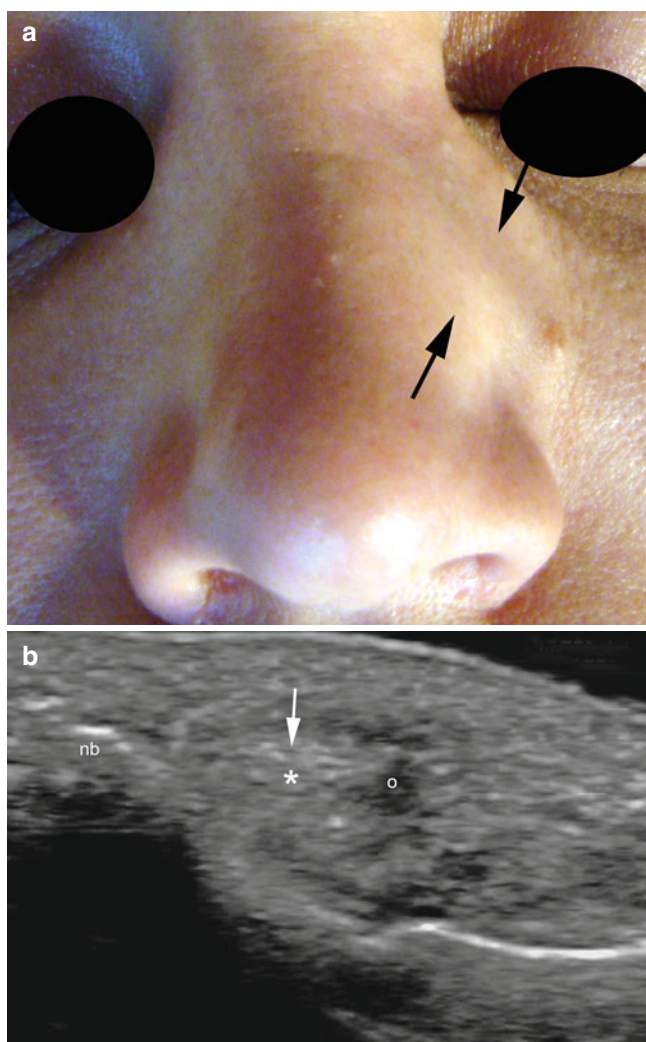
(a, b) Complication of polymethylmethacrylate (PMMA) after Botox injection. (a) Clinical image demonstrates a left paranasal lump (*arrows*) that developed immediately after a Botox injection in the glabellar region. The patient presented with a history of PMMA injection in the left paranasal region for repairing a nasal fracture 5 years previously (revealed after the Botox injection). (b) Grey scale ultrasound image (transverse view, left paranasal region) shows subcutaneous hyperechoic dots (*, *arrow*) with mini-comet-tail artifact surrounded by hypoechoic inflammatory/granulomatous tissue (o). *Abbreviation: nb* nasal bone
